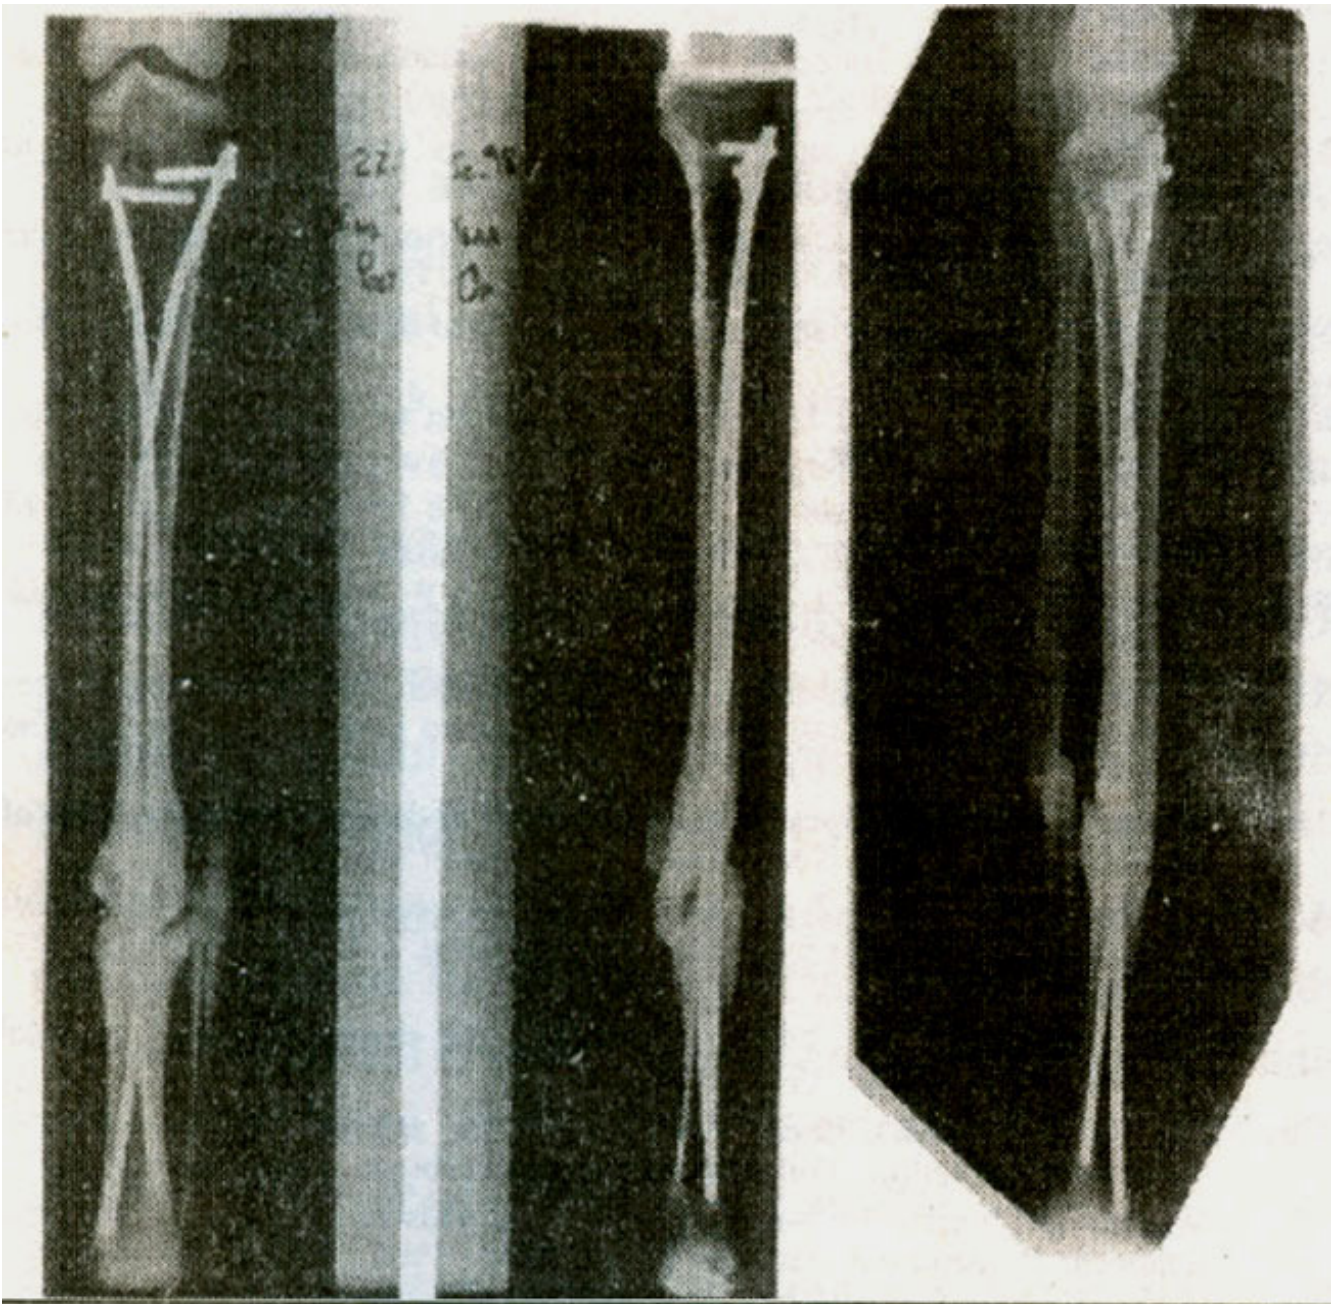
Clinical radiographs (A) AP and (B) lateral views at 9 months after fixation of an unstable fracture at the junction of middle and distal third of tibia fixed with Ender nails. A hypertrophic non-union at the fracture site established which required exchange nailing with a reamed interlocking nail. Clinical radiograph (C) of another stable fracture, one year post-operatively, at the junction of the middle and distal third of tibia, which developed a hypertrophic non-union.
